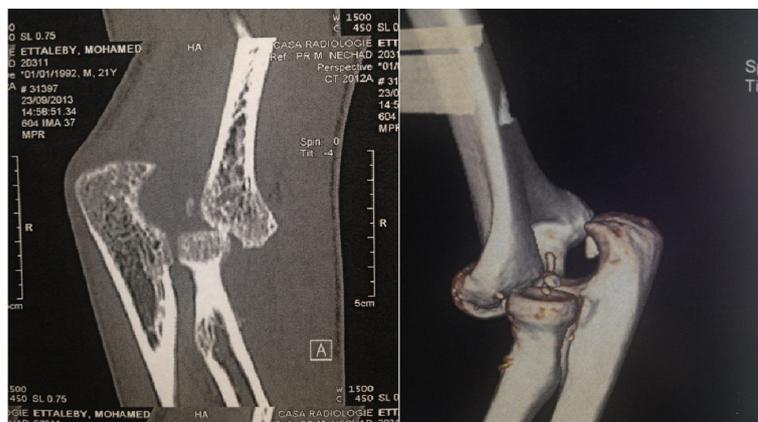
CT-scan of a neglected dislocation of the elbow presence of intra-articular foreign bodies.
